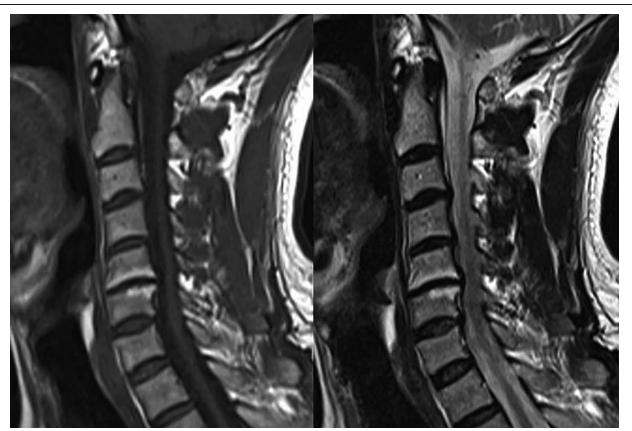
T1-sequence (left) and T2-sequence (right) images demonstrate C5-C6 with MC2 on MRI.
